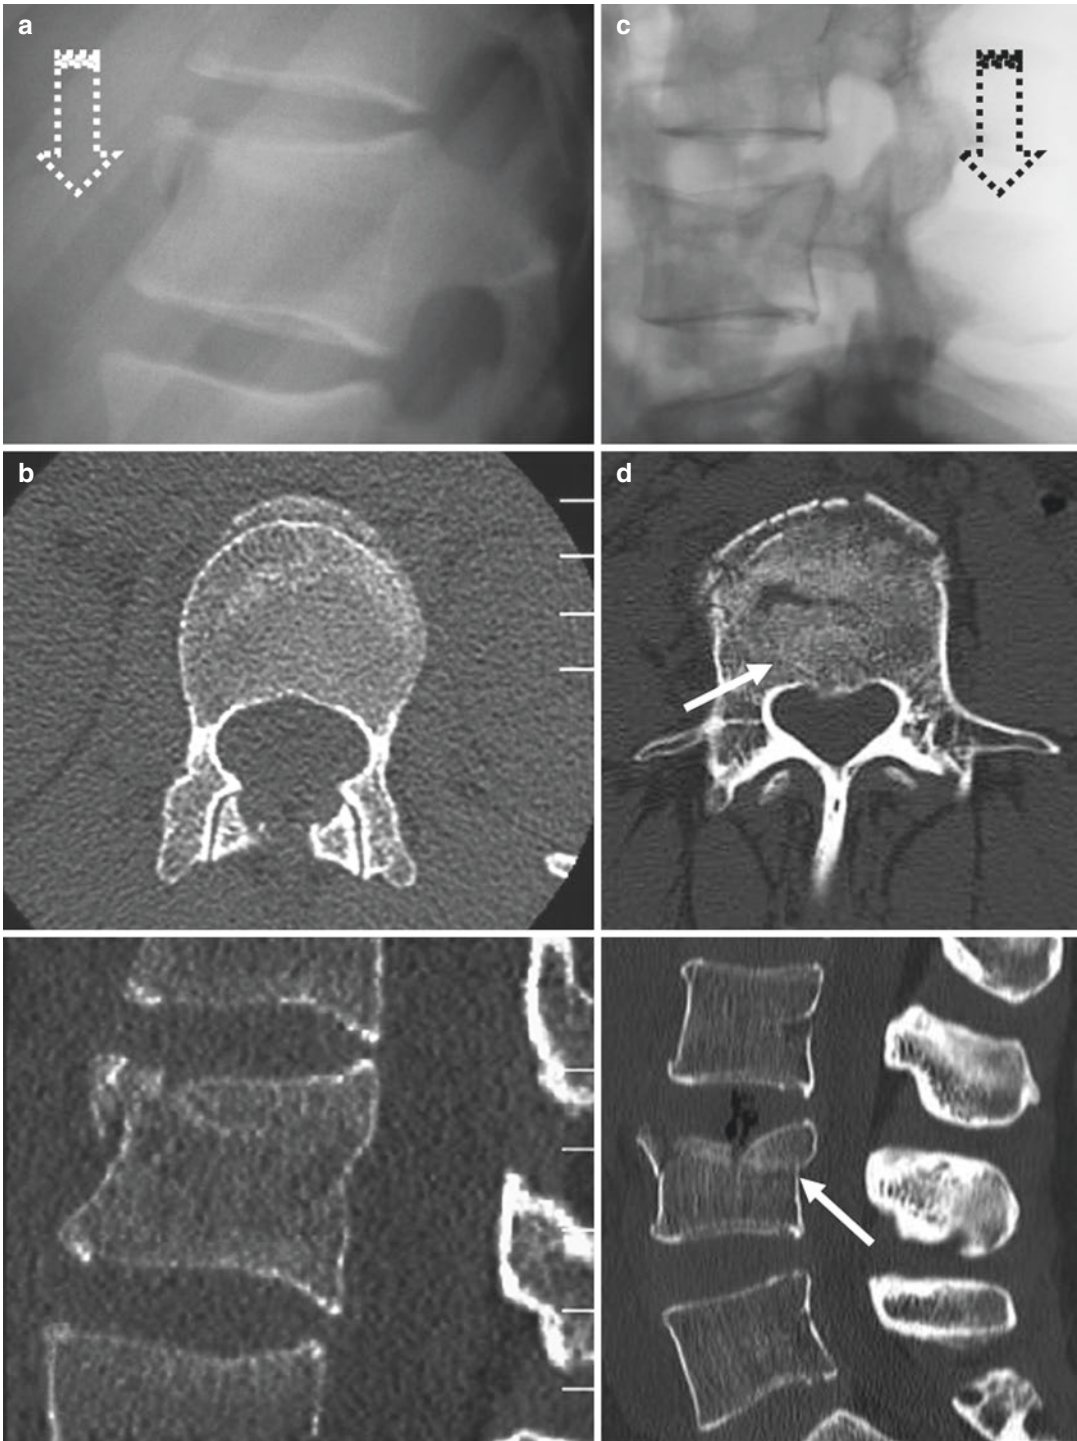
Lumbar and thoracic fractures by axial loading injury mechanism (*dashed open arrows*): potential and limitation of radiography (two different patients). In both patients, radiographs (a, c) clearly show the reduction in height of the vertebral body, resulting from the axial loading injury mechanism. Source axial and 2-D reformatted
